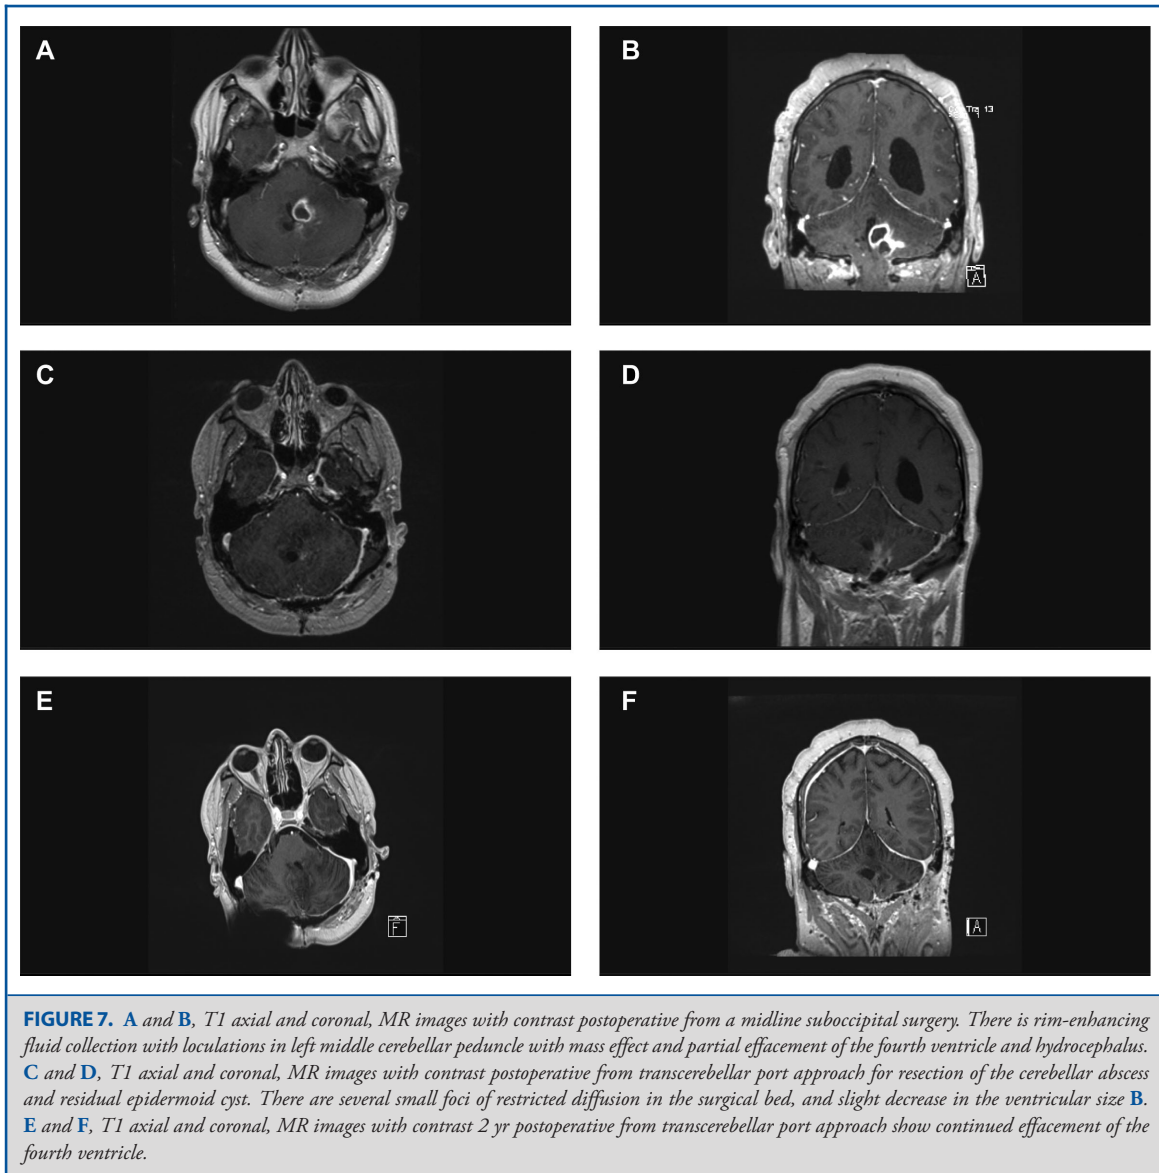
A and B, T1 axial and coronal, MR images with contrast postoperative from a midline suboccipital surgery. There is rim-enhancing fluid collection with loculations in left middle cerebellar peduncle with mass effect and partial effacement of the fourth ventricle and hydrocephalus. C and D, T1 axial and coronal, MR images with contrast postoperative from transcerebellar port approach for resection of the cerebellar abscess and residual epidermoid cyst. There are several small foci of restricted diffusion in the surgical bed, and slight decrease in the ventricular size B. E and F, T1 axial and coronal, MR images with contrast 2 yr postoperative from transcerebellar port approach show continued effacement of the fourth ventricle.
